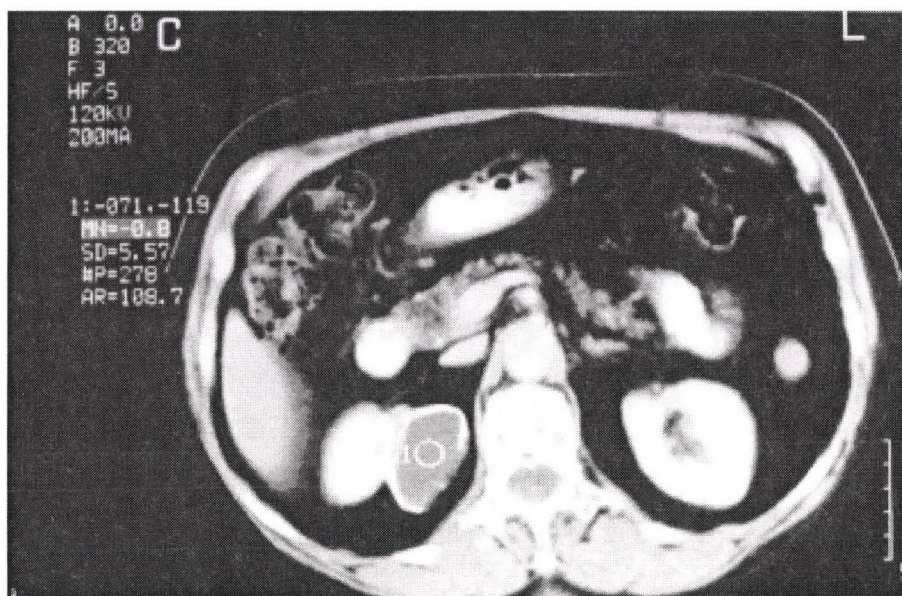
CT imaging shows the egg-sized cyst localised on the upper pole of the right kidney
